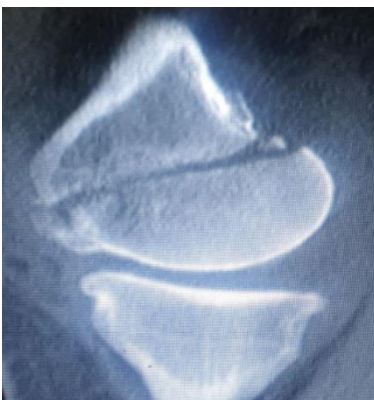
Sagittal view cut of computed tomography (CT) scan showing unusual fracture pattern similar to Salter-Harris type III fracture in children
